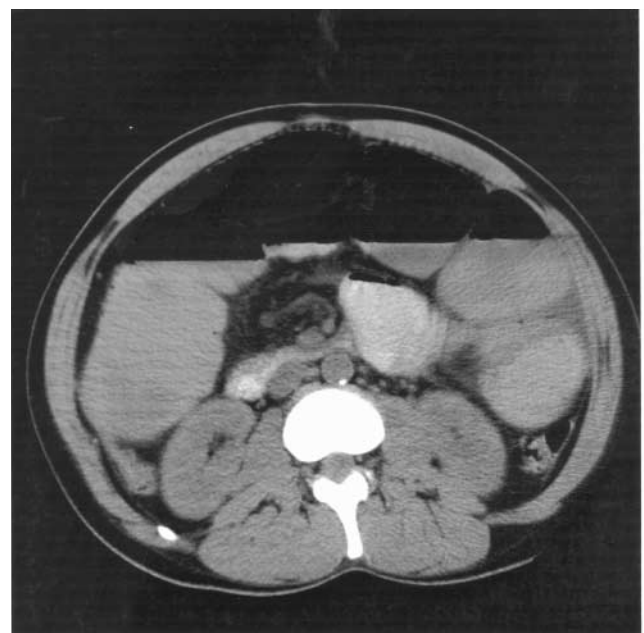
CT scan of abdomen on day 3
